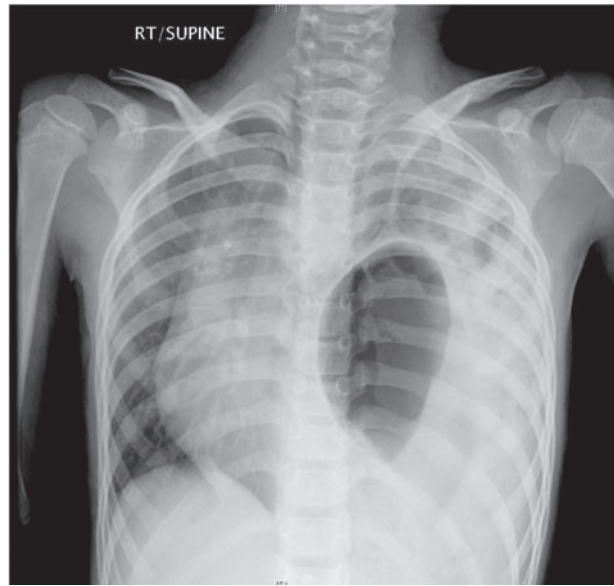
Chest radiograph showing the gastric bubble and bowel loops in the left hemithorax with mediastinal shift to the right side.
